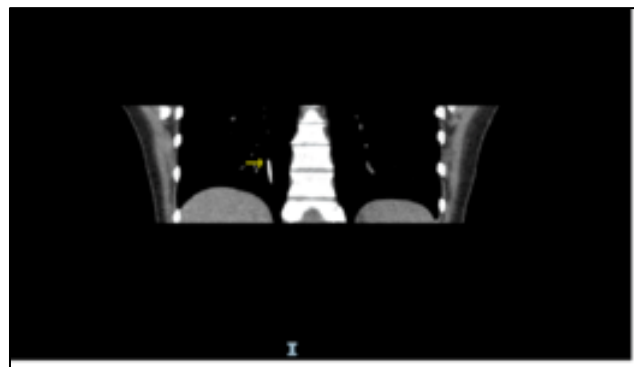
CT Chest Coronal View showing implanon in the subsegmental right lower lobe pulmonary vessel
